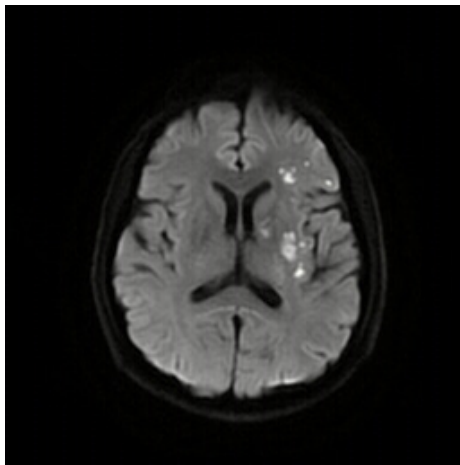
DWI examination in the first patient. DWI, diffusion weight imaging.
